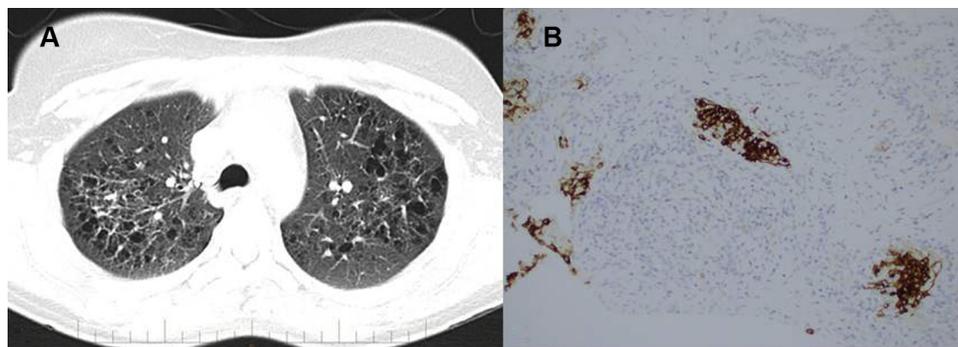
High resolution chest CT showing thin walled cystic changes (A) and CD1a histiocytes on open lung biopsy, $\times 400$ magnification (B). CT = computed tomography.
